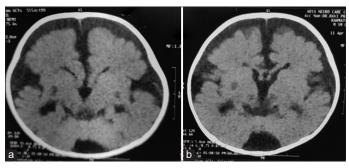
(a and b) Non-contrast computed tomography head showing hypodense foci in bilateral basal ganglia and thalami and in periaqueductal grey region with cerebral atrophy more prominent in bilateral fronto-temporal regions causing marked widening/ enlargement of sylvian fissures and interhemispheric fissure
